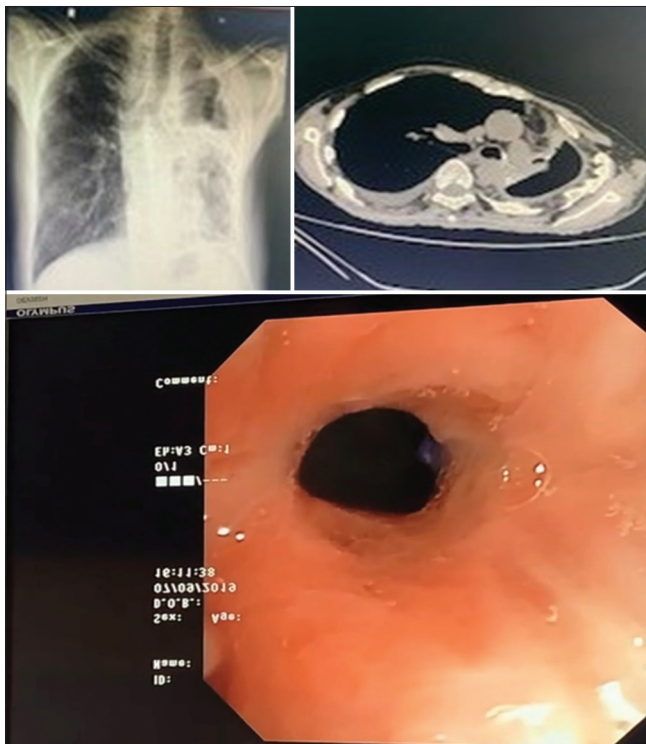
CT chest showing central bronchopleural fistula and its bronchoscopic view
